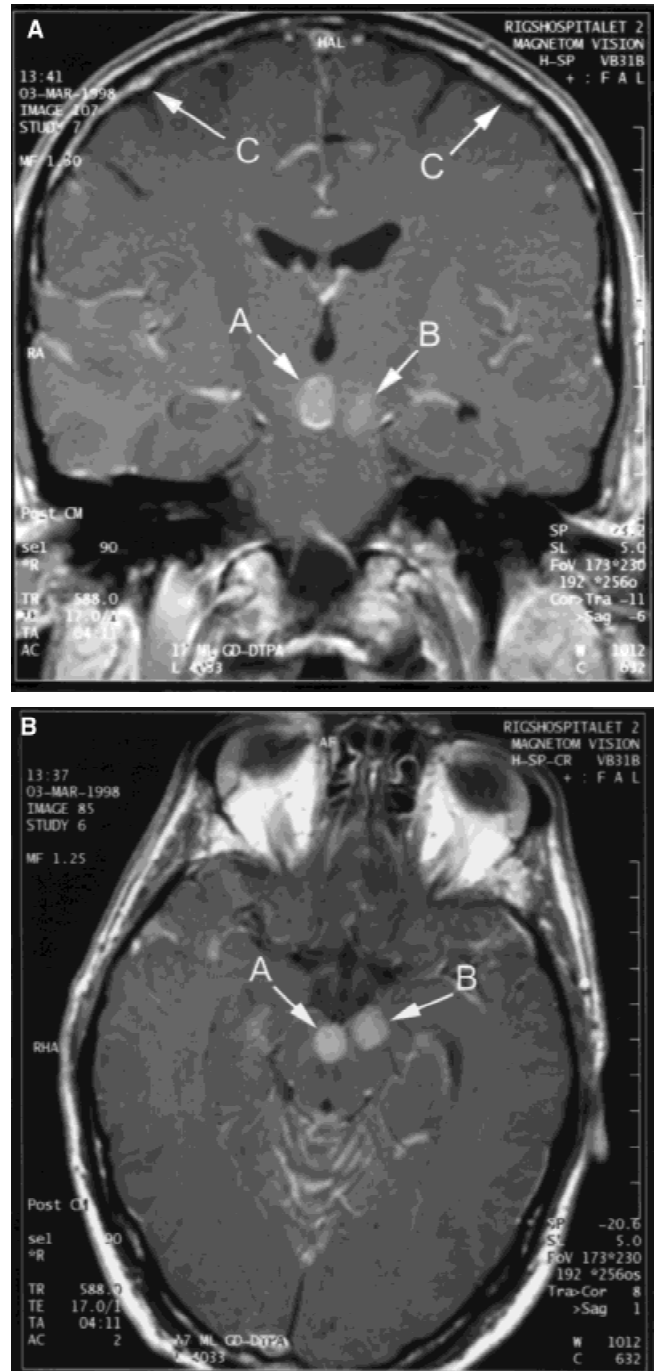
Coronal (A) and axial (B) contrast-enhanced T1-weighted MR image showing diffuse enhancement in the meninges (C) and localized lesions in the cisterna interpeduncularis (A) and the left cerebral peduncle (B).
